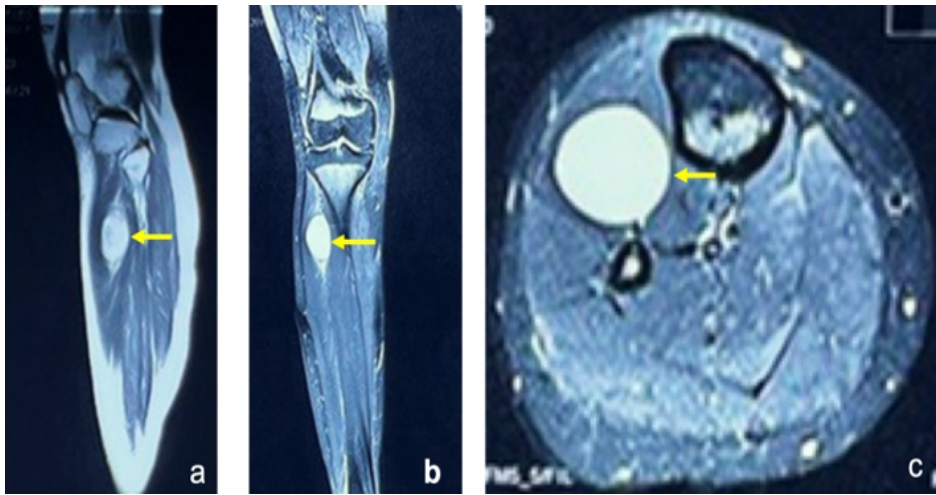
T2 sagittal, STIR coronal, and axial magnetic resonance imaging images (a, b, c) of the left upper leg demonstrate an oval T2-hyperintense encapsulated lesion (arrow) in the anterolateral intermuscular compartment.
